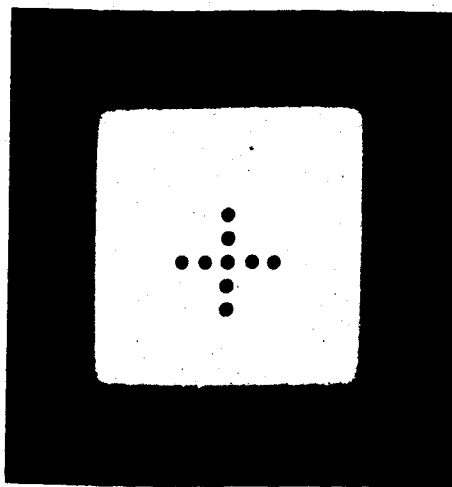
Radiograph of control plate
